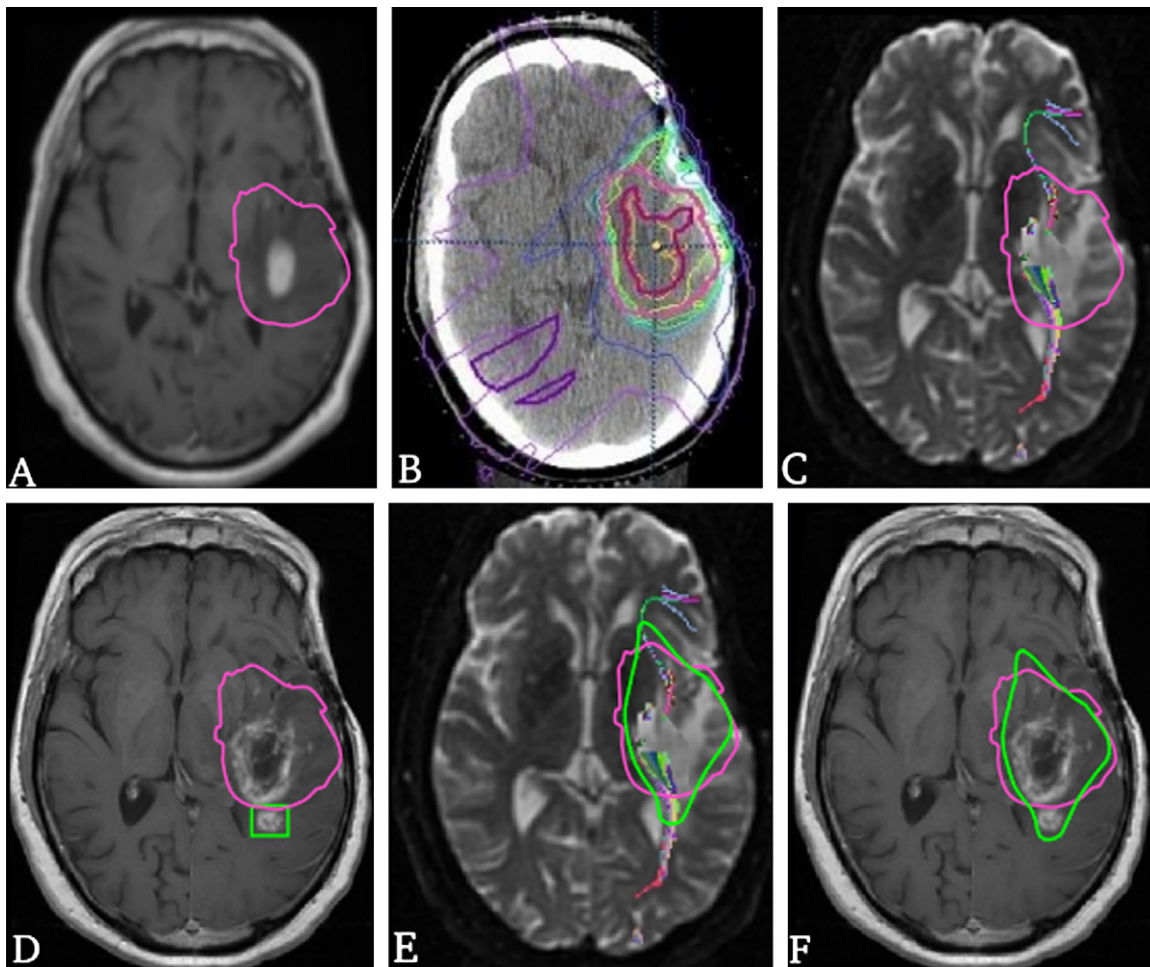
(A) T1-weighted postcontrast image showing the primary anaplastic astrocytoma and treatment margin (pink line, 90% isodose) obtained from the treatment plan by computed tomography (B). (C) Diffusion tensor imaging reference image ($b = 0$) taken at the same time point showing all major diffusion paths passing through the tumor. Two major bundles pierce the treatment margin. (D) T1-weighted postcontrast image 3 months after the time point of (A) showing recurring tumor (green box) just outside of the treatment margin and in the same location as the major posterior bundle (C). (E) The treatment plan that was used for stereotactic radiotherapy (pink line) and the proposed anisotropic treatment plan (green line) with increased dose along the two prominent bundles emanating from the primary tumor and reduced margin along other directions. (F) Depiction of the original (pink) and proposed (green) treatment plans on the follow-up T1-weighted postcontrast image. Our contention is that the proposed plan might have stalled or may have even prevented the onset of the secondary tumor.
